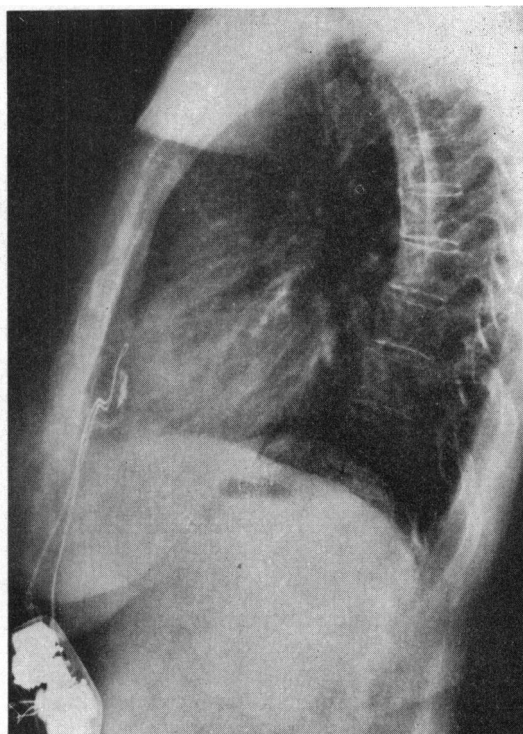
Lateral chest x-ray film showing the proximity of the epicardial electrode to the anterior chest wall.
